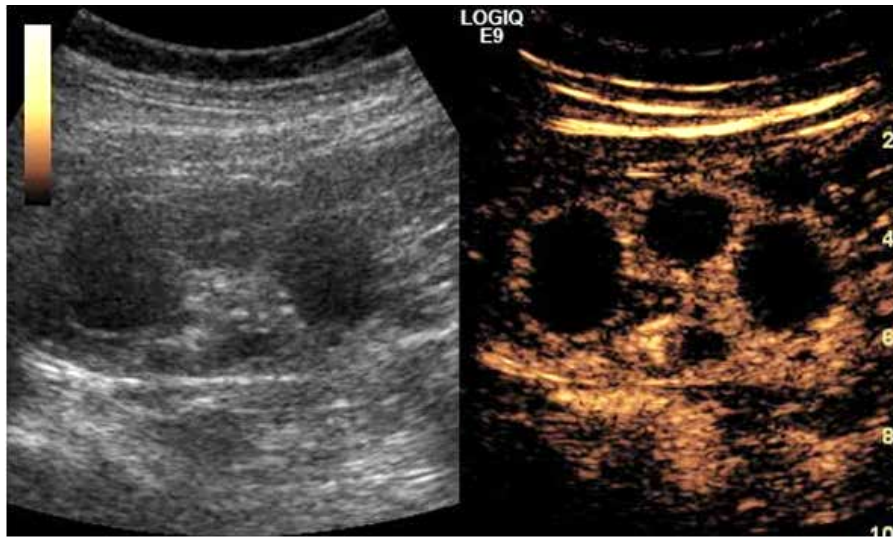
Contrast enhanced ultrasound performed of a kidney with previously indeterminate lesions demonstrates multiple benign renal cysts. These are characterized by thin-walls and no internal enhancement or vascularity.
